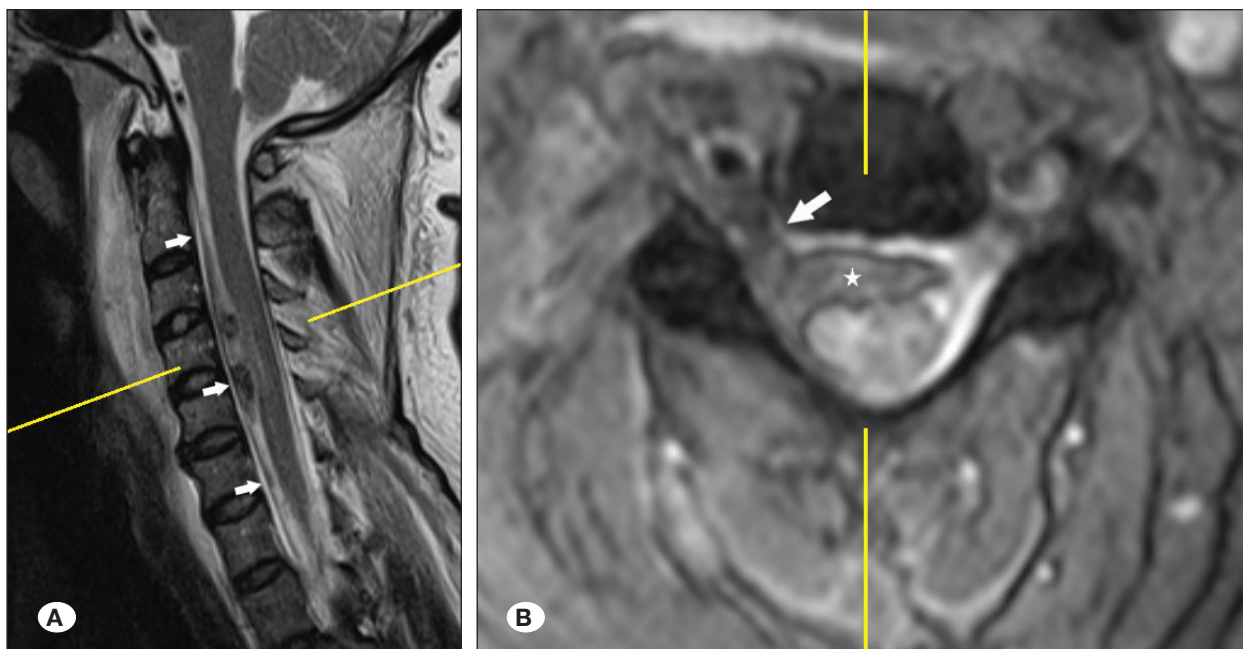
Cervical spine MRI. A) T2 sagittal sequence showing an anterior spinal hematoma (white arrows) that extends from C2-C7 with subdural characteristics due to preservation of peridural fat. B) T2 axial sequence, showing right anterolateral subdural hematoma (white star), causing posterior spinal cord compression limited by a denticulate ligament. The epidural component extends from the C4 to C5 right foramen (white arrow).
